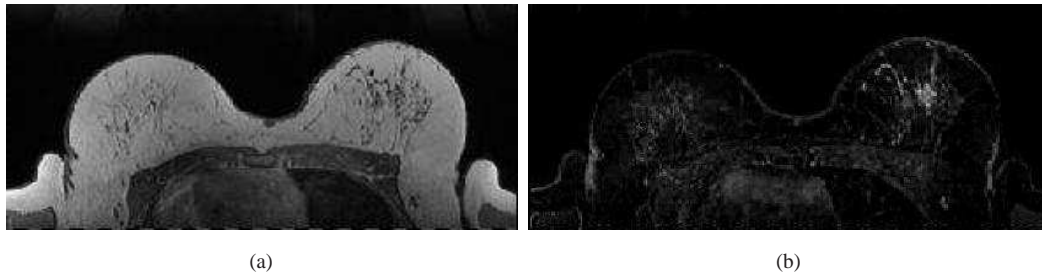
An example of a transverse slice coming from (a) a pre-contrast MRI and (b) the subtraction image of the pre-contrast from the post-contrast image, showing an enhancing lesion (Invasive Ductal Carcinoma).
